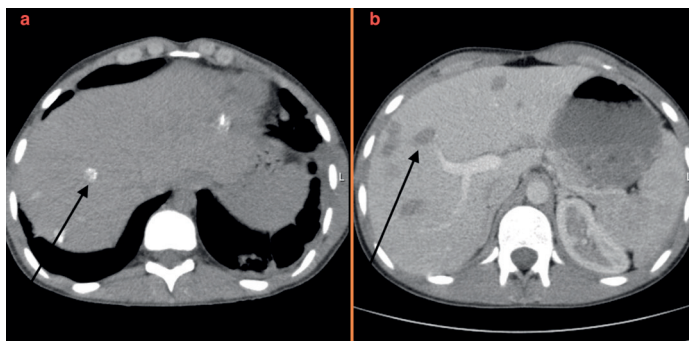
Unenhanced abdominal CT b. Contrast enhanced abdominal CT
